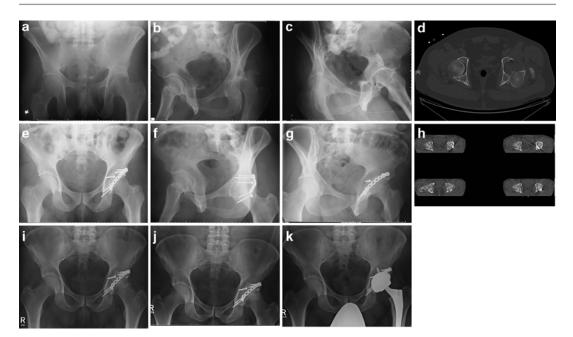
A case presentation of a 40-year-old patient who sustains a posterior wall fracture of the acetabulum with subluxation of the femoral head. The patient reported no pre-injury hip symptoms. (a–c) AP, obturator oblique, and iliac oblique radiographs of a patient with a displaced posterior wall acetabular fracture. (d) CT scan demonstrating displacement of the posterior wall fracture and subluxation of the femoral head. (e–g) AP, obturator oblique, and iliac oblique radiographs of postoperative reduction of the acetabulum articular fragment and femoral head with fixation of the posterior wall. (h) CT scans after surgical reduction and fixation. Beginning from the *top left* the images
